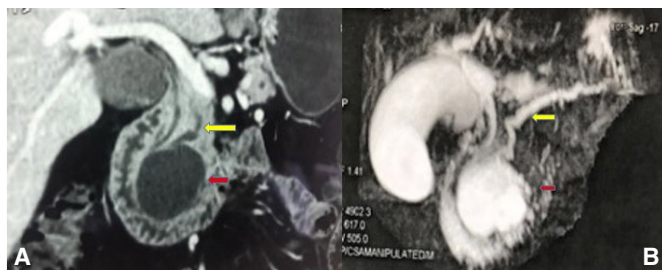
(A) CT showed a thin-walled cyst (red arrow) in the head of pancreas 49 x 45 mm with compression of the CBD and MD (yellow arrow). (B) MRI/MRCP pancreatic head cystic lesion with thick wall (red arrow) and compression of the CBD and the MD (yellow arrow).
